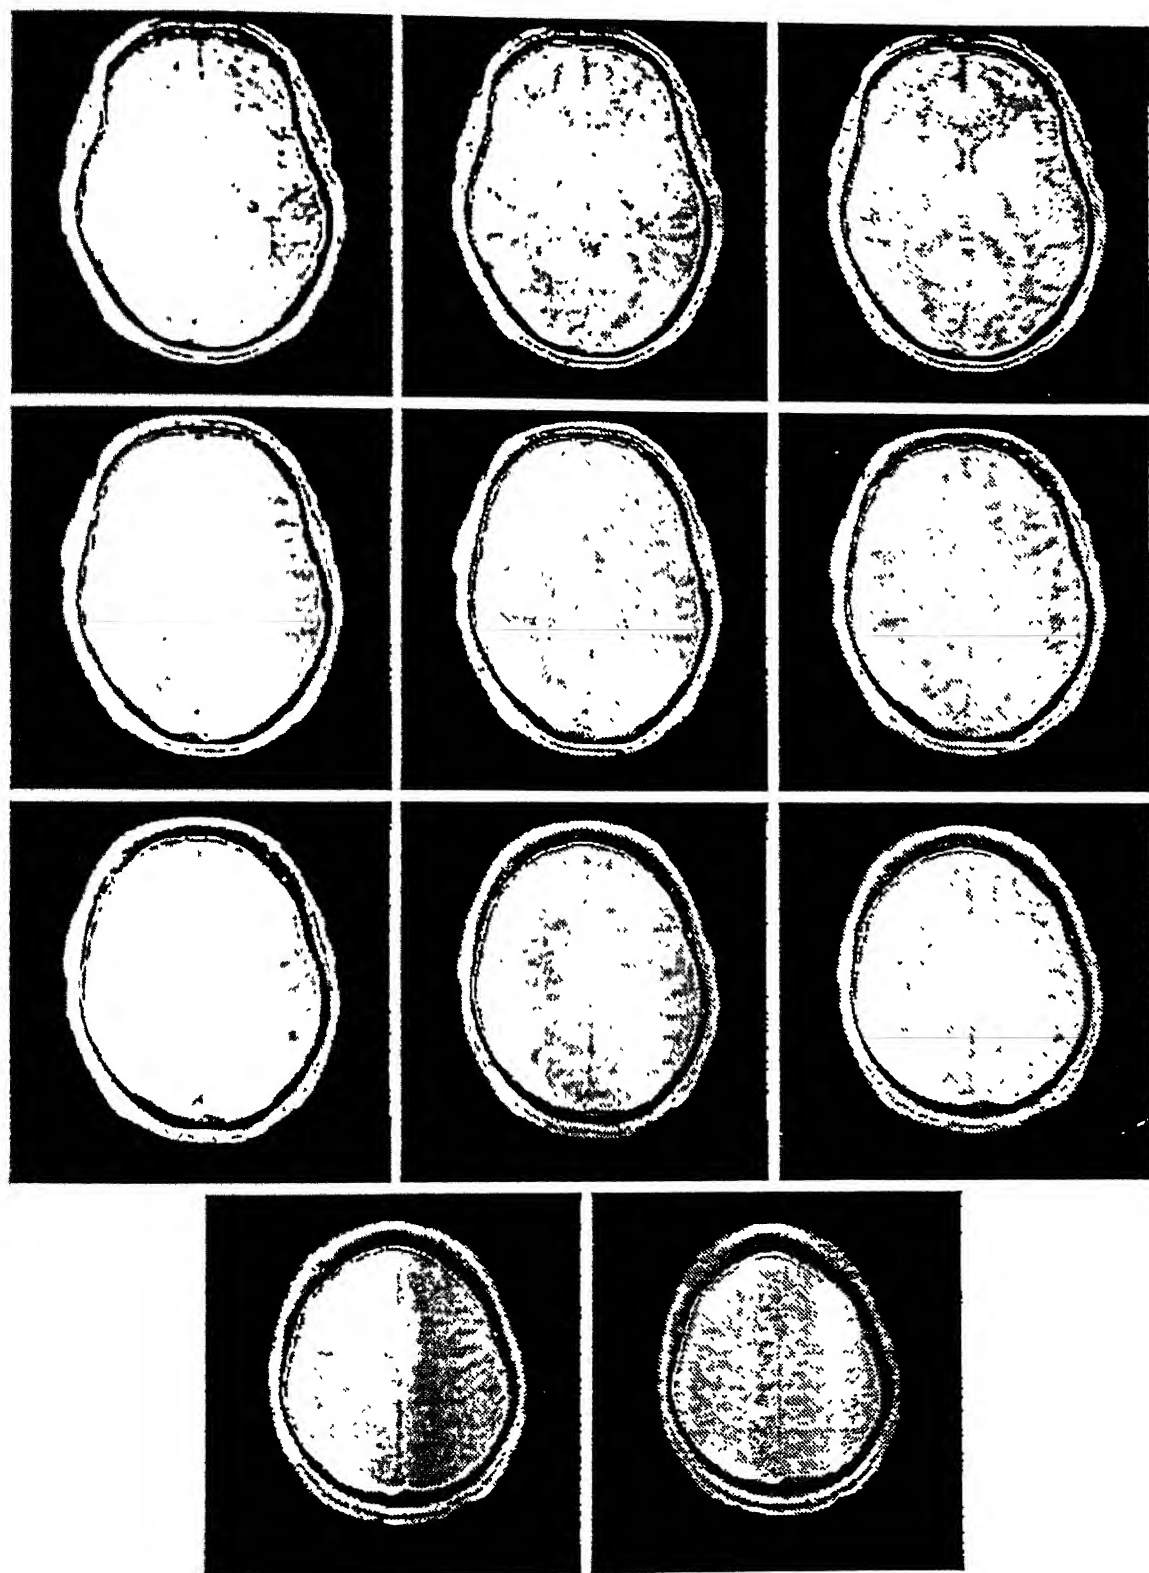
The Brain Mask for MRI Data Set 1 overlaid on the PD-weighted scan: Slices 12-22.
